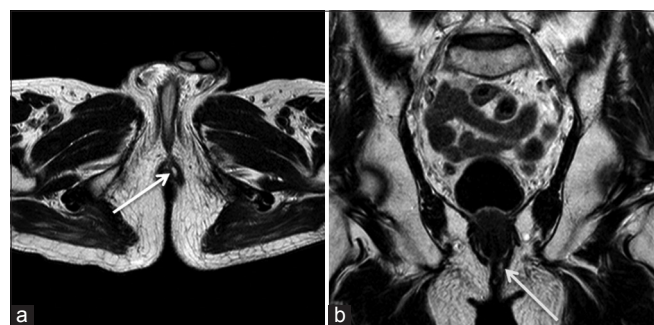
(a) Axial T2-weighted (T2W) showing an intersphincteric hyperintense tract between the two anal sphincters on left side (white arrow). (b) Coronal T2W showing an intersphincteric infralevator hyperintense tract on left side (yellow arrow)
